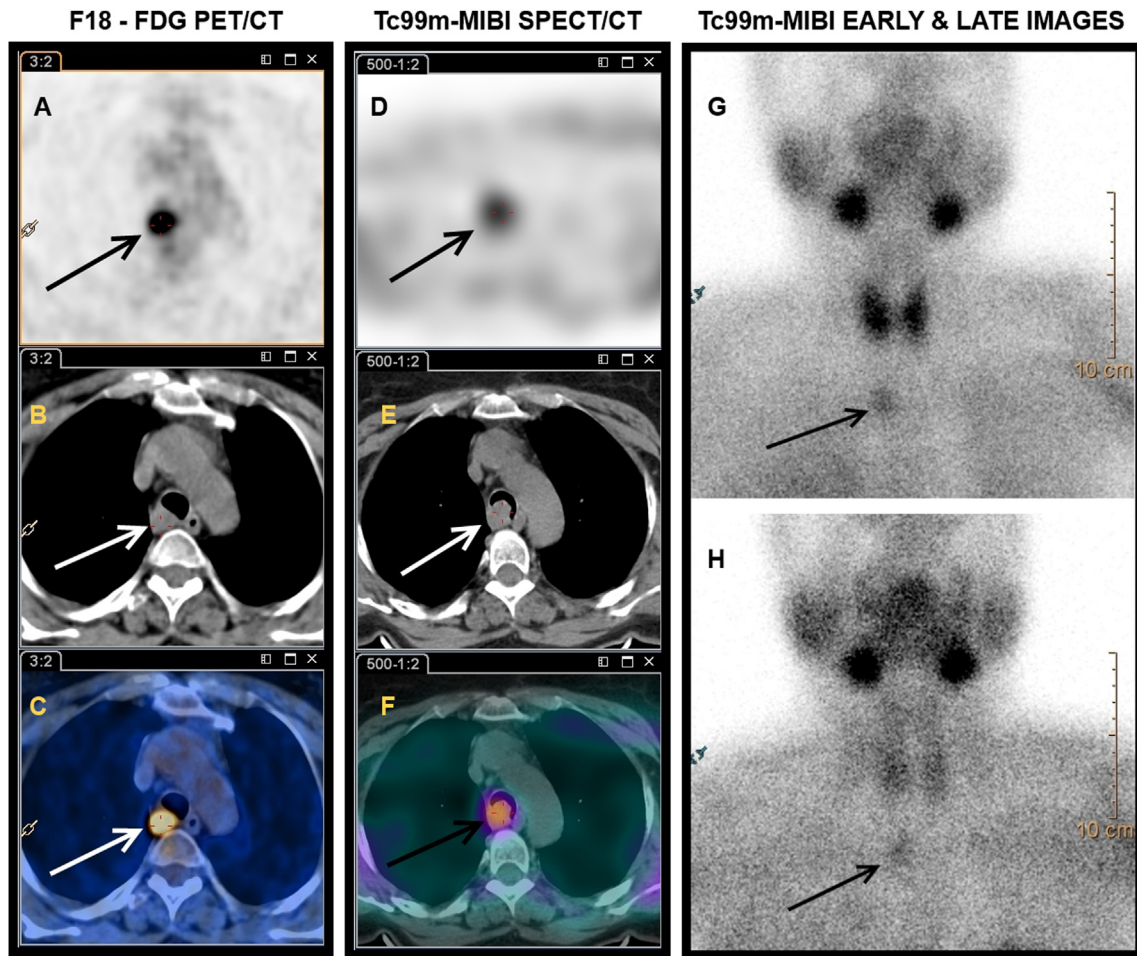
On the early images at 15 min (G) a focal increased uptake of ^{99m}Tc-MIBI was observed at mediastinum. Focal uptake continued at delayed images acquired after the second hour of injection (H). SPECT/CT was performed in order to determine the exact localization of the lesion. Lesion was located in the right posterolateral wall of trachea similar as PET/CT (D: SPECT images, E: CT images, F: SPECT/CT fused images).
